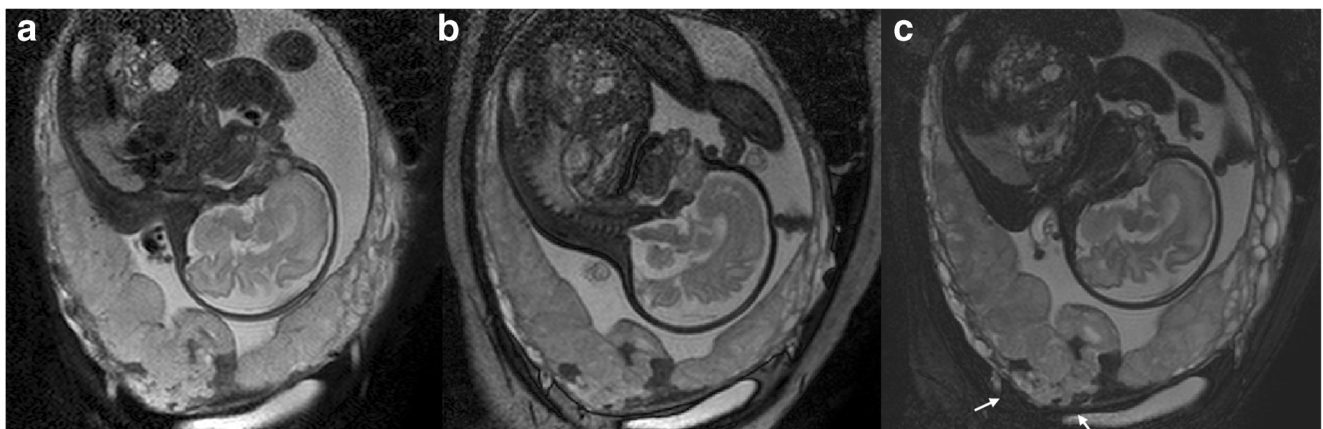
Representative case of confirmed placenta percreta, with PPAS shown in different MRI sequences. a SSFSE; b the same layer in b-SSFP; c the same layer in T2W b-SSFP. The placenta protrudes through the wall of the uterus and several DIB were also observed
